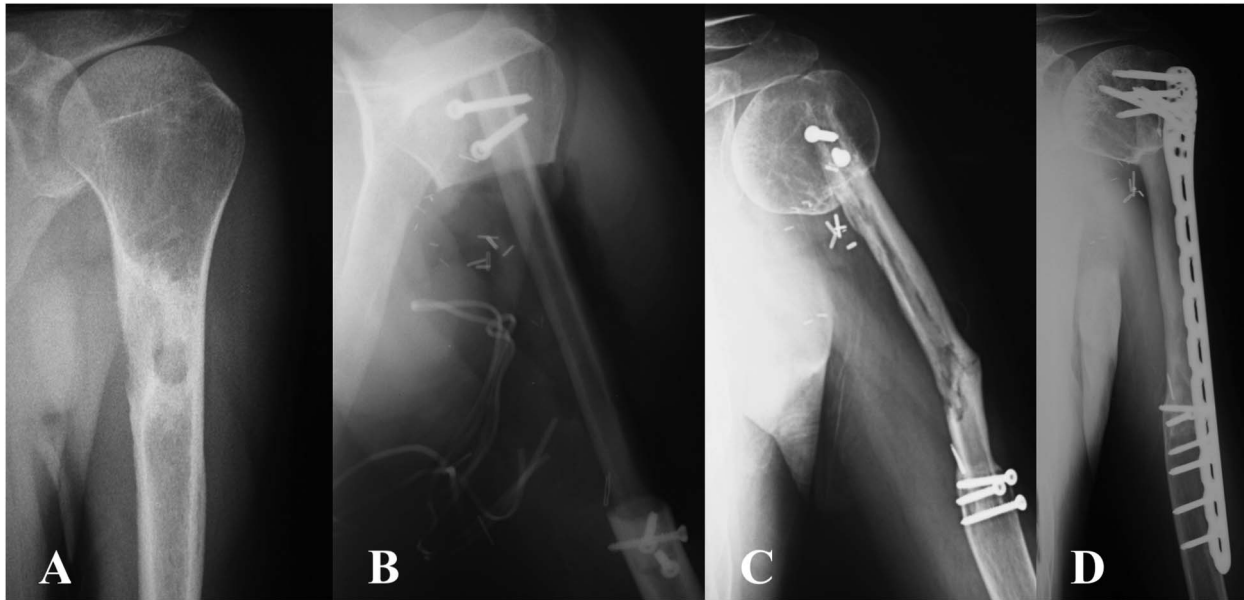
(A) This radiograph of a 31-year-old man shows humeral diaphysis involvement of a low-grade fibromixoid sarcoma. (B) The patient underwent intercalary resection of the humerus and reconstruction with VFG and only screw fixation. (C) The patient had graft fracture because of a fall 15 months after the index surgery. (D) This radiograph shows fracture healing after surgical revision with bridging plate fixation.
